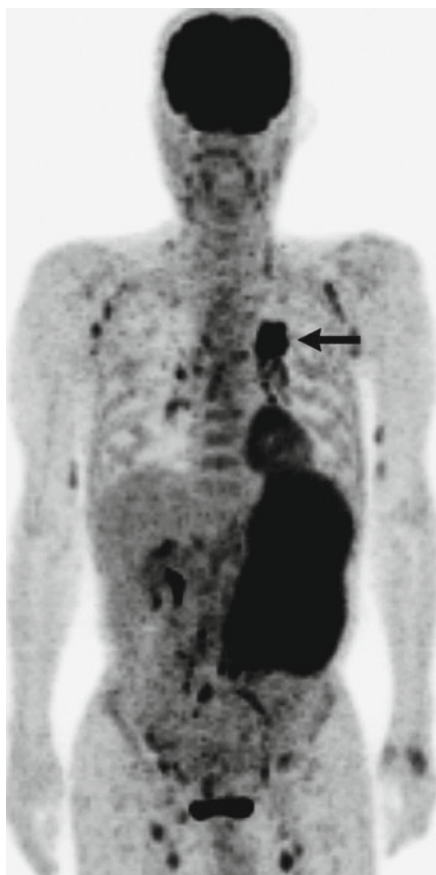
Initial FDG-PET image of a mantle cell lymphoma. Abnormal uptake is observed in the bulky mass in the left abdomen and in the axillary, hilar, and inguinal lymph nodes bilaterally. Higher uptake was observed in left hilar area (*arrow*), which was finally diagnosed as adenocarcinoma of the lung
